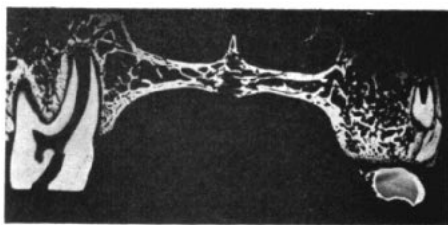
Soft x-ray radiograph showing marked midline radiolucency.
